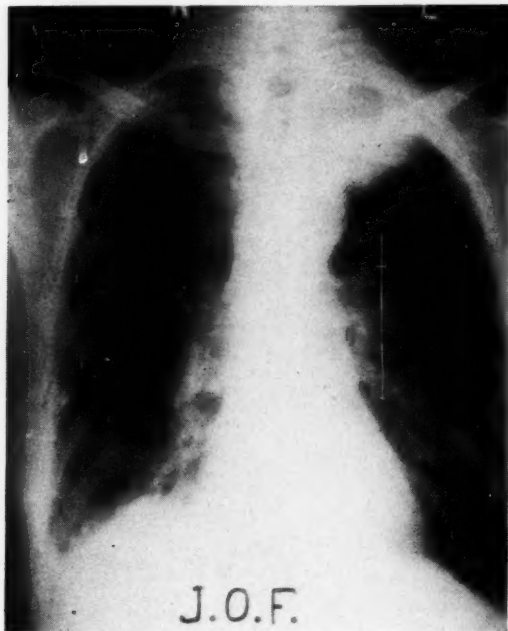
Homogenous density left superior mediastinum. X-ray shows destruction of third rib posteriorly. Horner's syndrome present. Diagnosis: Superior sulcus tumor. No operation.
